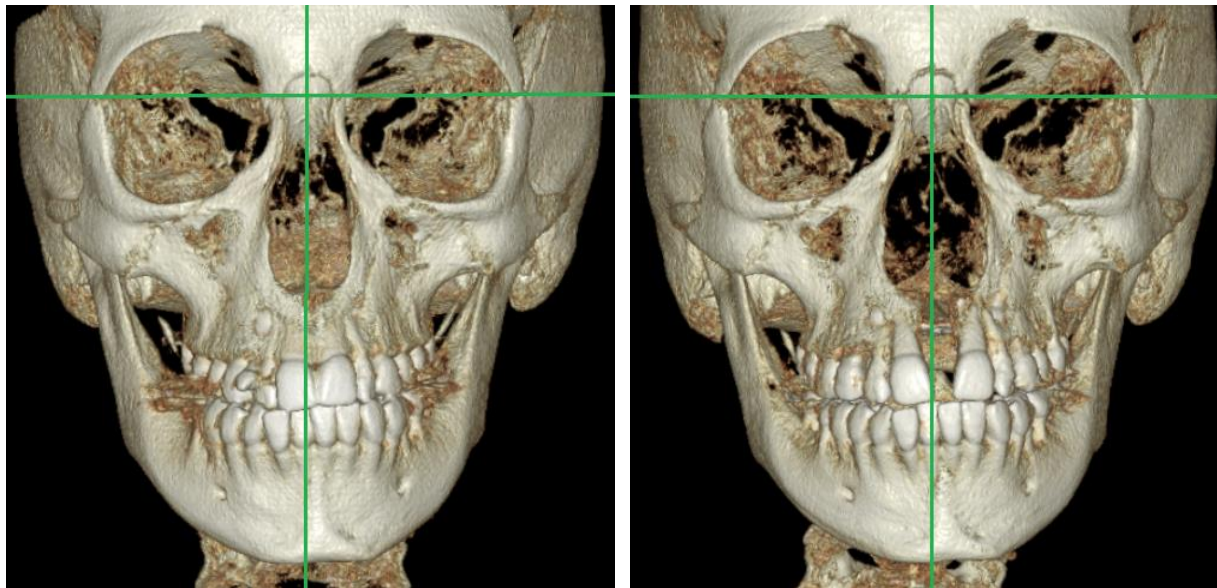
Reference lines used in conventional 2D postero-anterior cephalometrics for a MSE patient. A: pre-expansion and B: post-expansion. Anterior nasal spine is clearly located on the left side of the vertical reference line in the pre-expansion CBCT.
